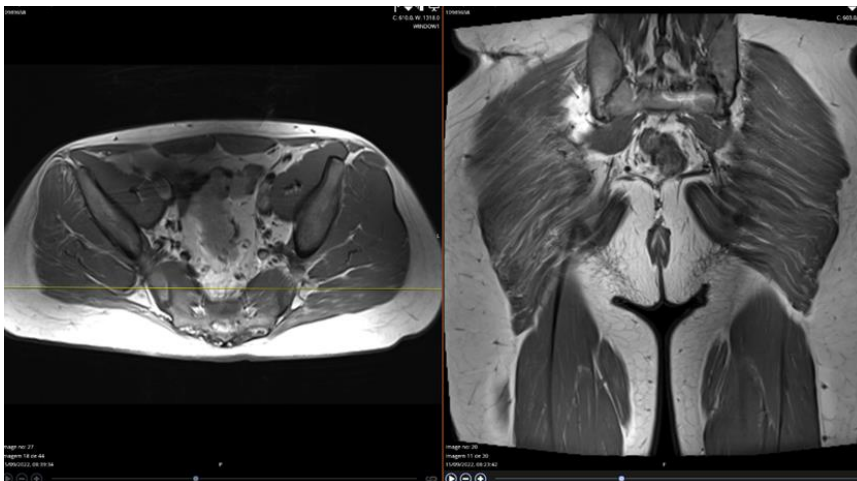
MRI T1 sequence (axial and coronal planes) showing scarring of maximus gluteus
